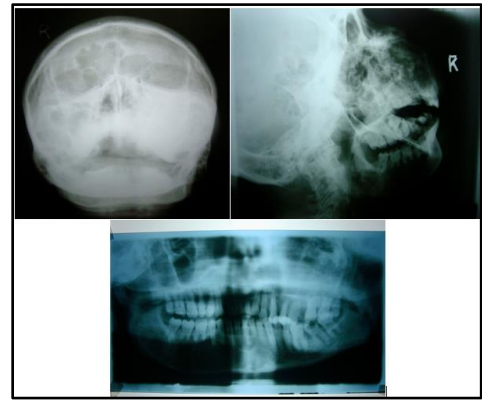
Orthopantomograph and Extra-oral views of skull (Water's and Lateral oblique) showing complete opacification over the left maxilla and a corticated radiolucency with few radiopaque flecks over the right mandible.
